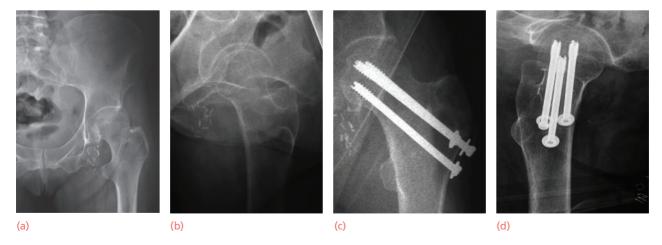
Femoral neck injuries – treatment (a,b) This Garden stage II fracture has been stabilized with three cannulated screws. (c,d) An optimum position for the screws is: one to support the inferior portion of the neck (centrally); and another two, central in level, skirting the anterior and posterior cortices of the femoral neck on the lateral X-ray. It is important that the most inferior screw enters the lateral cortex of the femur proximal to the level of the inferior margin of the lesser trochanter.
